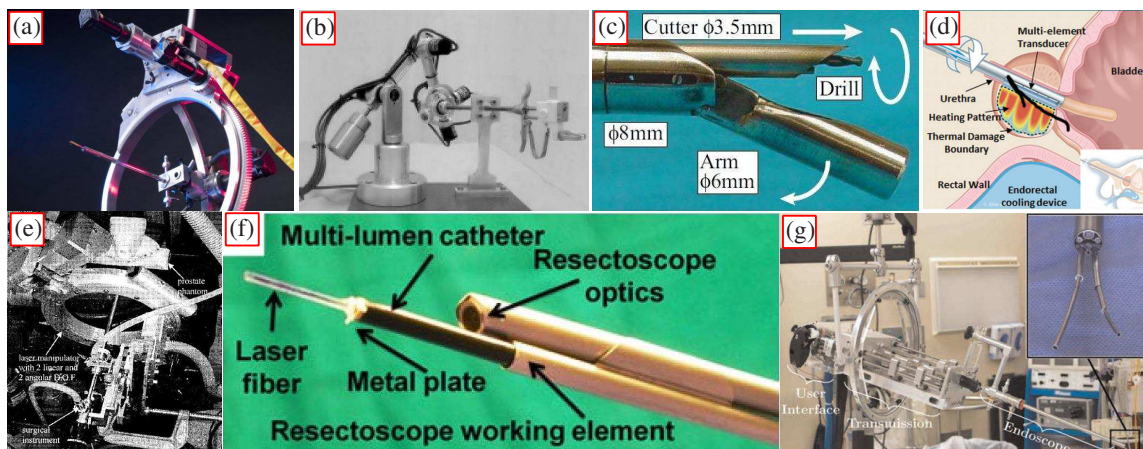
Transurethral robots for prostate surgery: (a) PROBOT, a 4-DoF motorized resectoscope for TURP (Image source: <http://www.imperial.ac.uk>) [36, 65, 66], (b) Master arm of telerobotic system for TURP [162]: 4-DoF motorized working element of a resectoscope, (c) 4-DoF tubular organ resection manipulator for TURP [140], (d) 2-DoF Magnetic Resonance imaging - controlled transurethral ultrasound applicator for thermal treatment of prostate cancer [164], (e) 4-DoF CALRP laser manipulator for TURP [166], (f) ASTRO: a 2-DoF multi-lumen catheter-like robot with integrated FBG sensor for contact force sensing toward HoLEP application [167], (g) A bi-manual 2x3-DoF concentric-tube based robot integrated in an offset endoscope for HoLEP [168].
